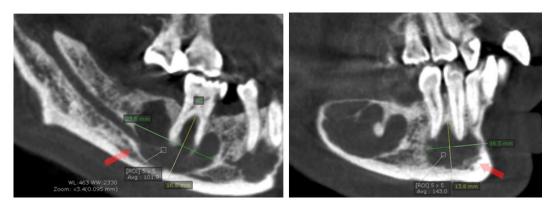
CBCT scan revealing multiple radiolucency on a mandible dextra
